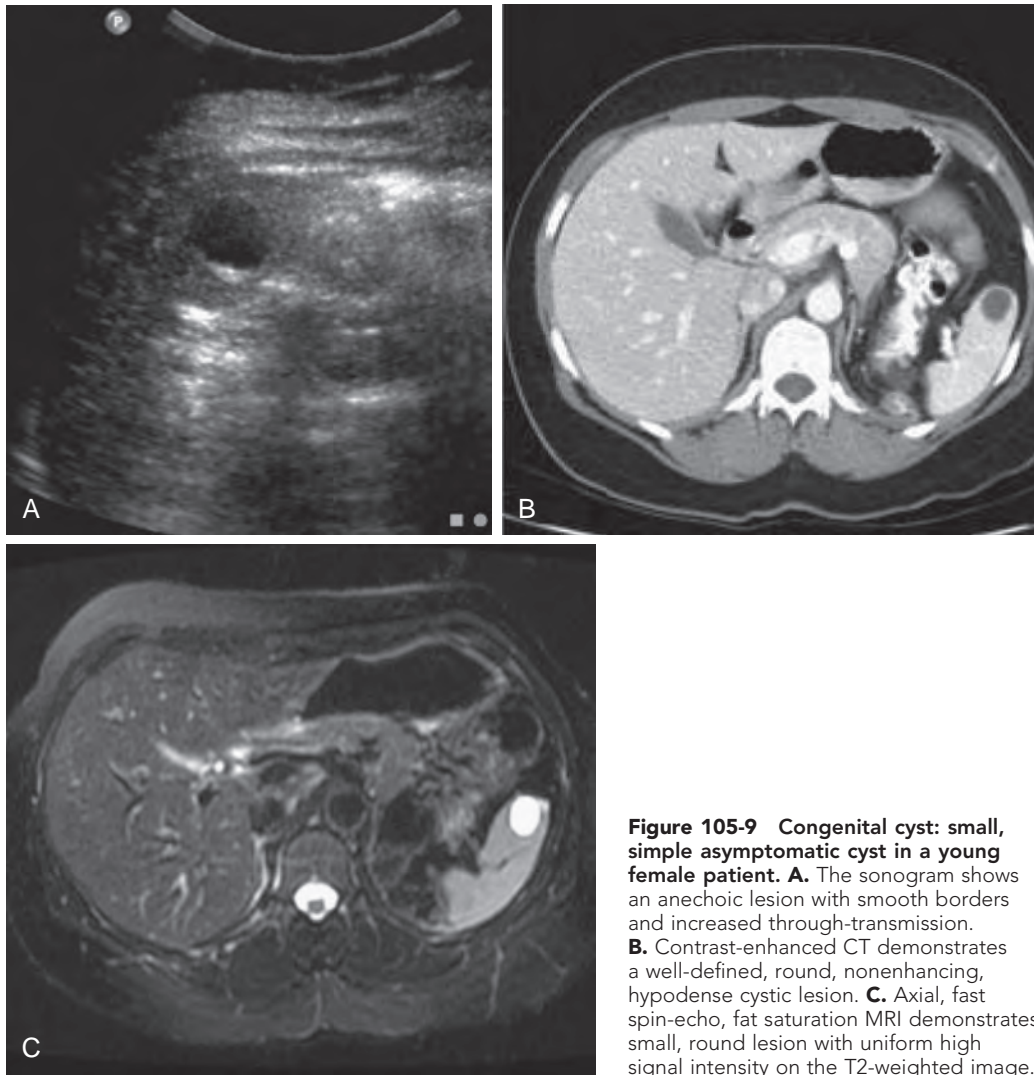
Congenital cyst: small, simple asymptomatic cyst in a young female patient. A. The sonogram shows an anechoic lesion with smooth borders and increased through-transmission. B. Contrast-enhanced CT demonstrates a well-defined, round, nonenhancing, hypodense cystic lesion. C. Axial, fast spin-echo, fat saturation MRI demonstrates small, round lesion with uniform high signal intensity on the T2-weighted image.
